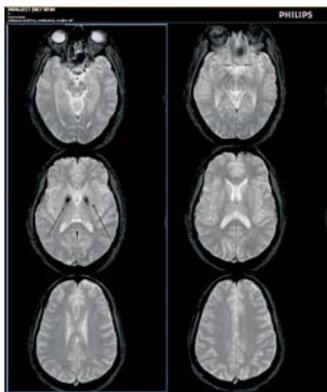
MRI (Brain) showing physiological symmetrical calcification in bilateral globus pallidus
